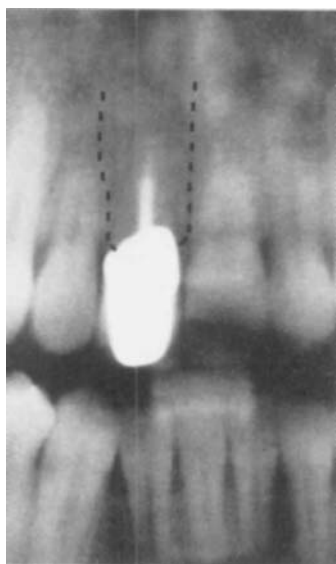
■ Preextraction radiograph marked to show extent of available bone.
